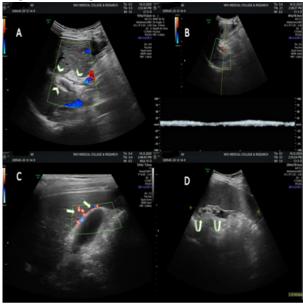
(A & B) Color Doppler and spectral analysis demonstrates echogenicity periportal (white arrowheads) along main portal vein its right and left branches and few segmental branches, significantly narrowing its lumen with monophasic hepatofugal flow. (C) Color Doppler demonstrates pericholecystic (white collaterals arrows). (D) Splenomegaly and dilated and tortuous splenic vein (curved arrows) are seen at the splenic hilum.
